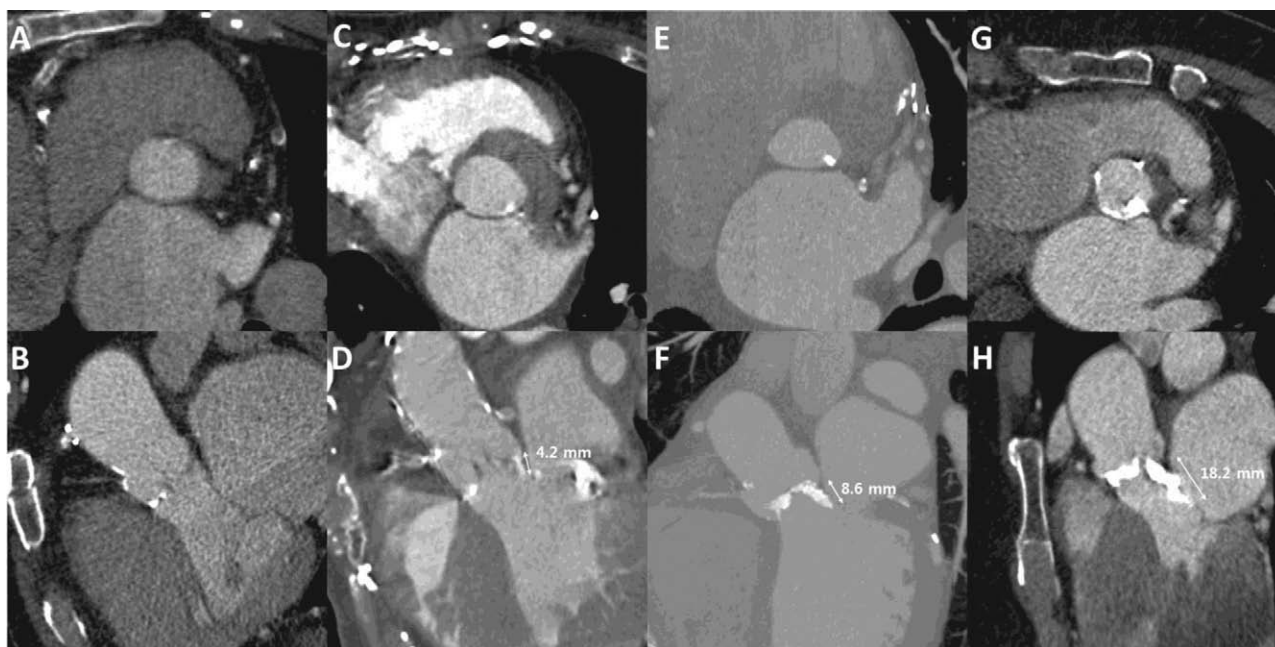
MDCT reconstruction of the LVOTs in 4 different patients undergoing evaluation pre-TAVR in double-oblique transverse (A, C, E, and G) and coronal (B, D, F, and H) projections displaying varying degrees of LVOT calcification: A, B, none; C, D, mild; E, F, moderate; and G, H, severe. LVOT indicates left ventricular outflow tract; MDCT, multidetector computed tomography; and TAVR, transcatheter aortic valve replacement.
